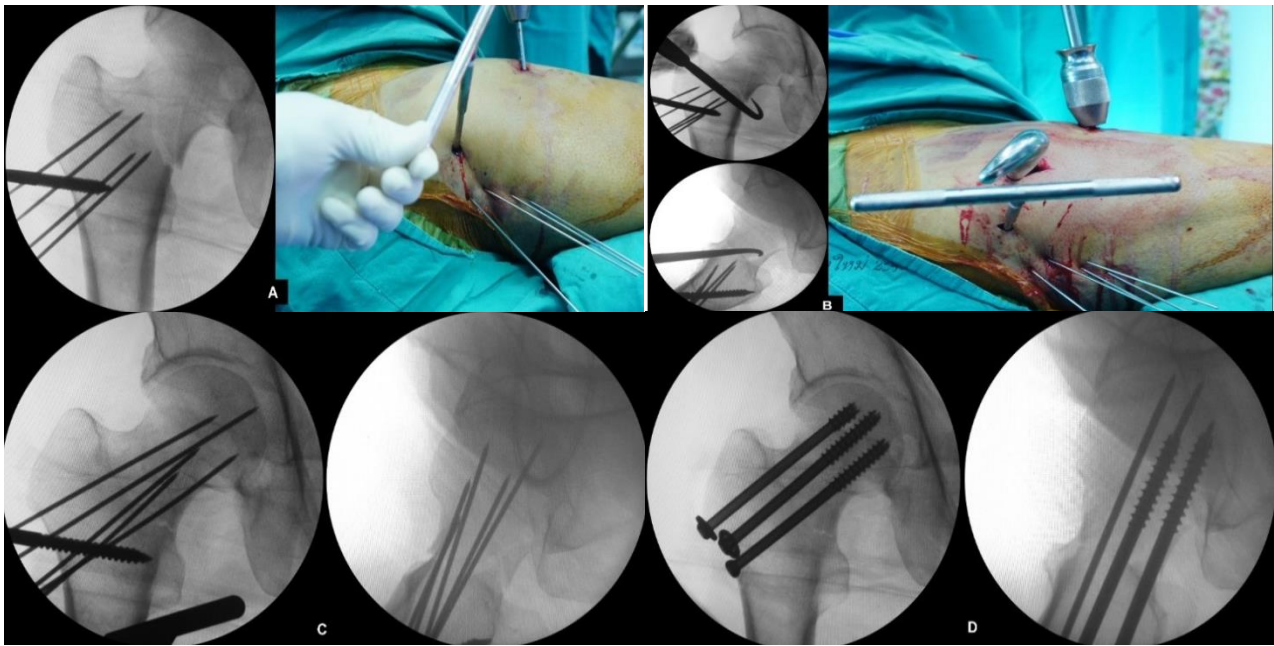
Intraoperative radiograph and image of a "ready to go pin" before reduction (A), reduction of the femoral neck using a bone hook with intraoperative anteroposterior (AP) and lateral radiographs (B), intraoperative AP and lateral radiographs showing temporary multiple pin fixation after closed reduction (C), AP and lateral radiographs showing cannulated screw fixation with reversed triangular configuration (D)
